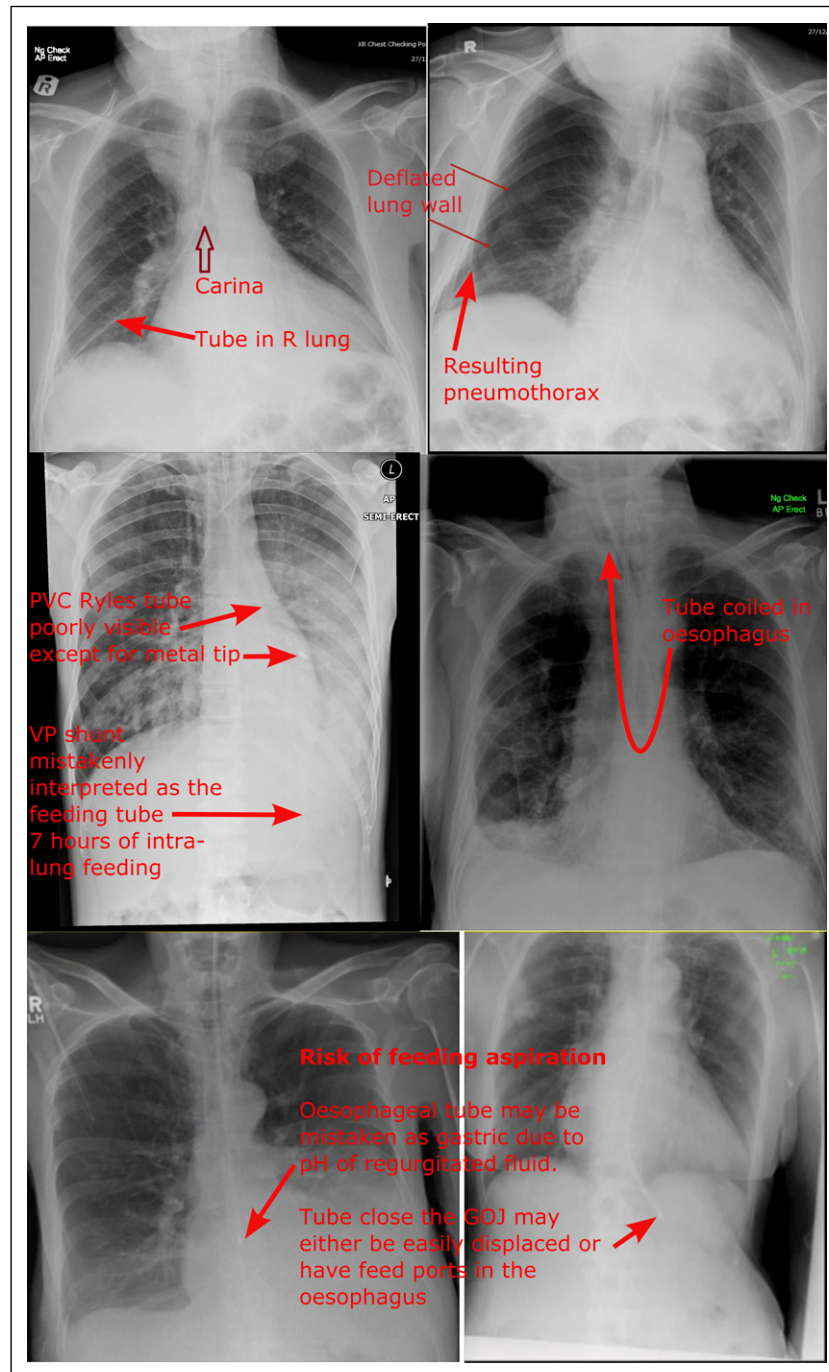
X-ray: Too late to prevent pneumothorax, misinterpreted and requiring tube re-positioning.
